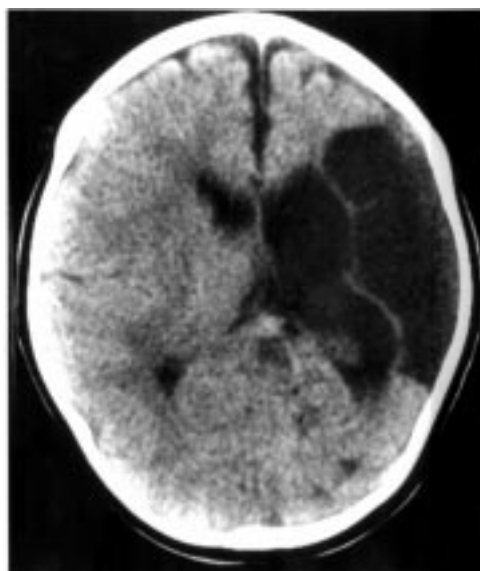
Computed tomogram showing intrauterine porencephalic cystic formation (two cavities) in a boy heterozygous for the factor V Leiden mutation combined with familial increased lipoprotein (a) values.
